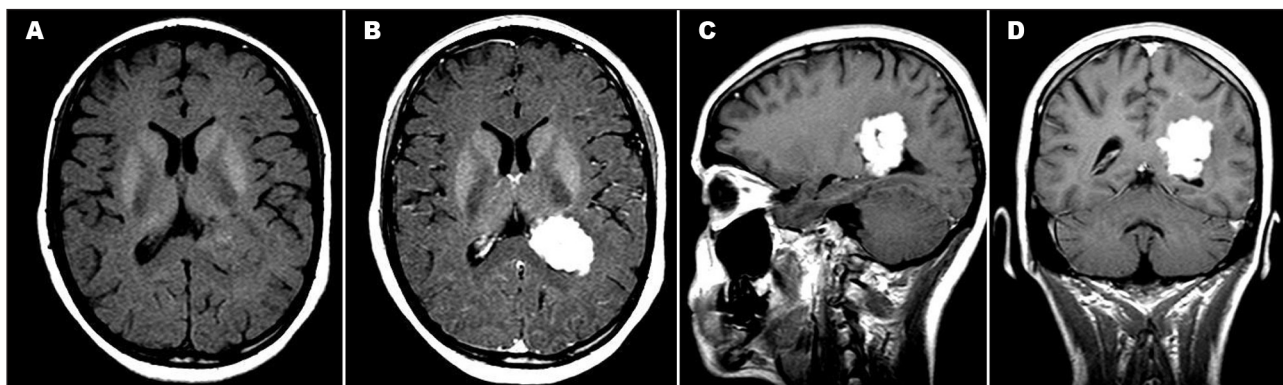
Brain T1-weighted MRI with a solitary 4 cm mass centred on the trigone of the left lateral ventricle. [A] Axial without gadolinium. [B] Axial with gadolinium. [C] Sagittal with gadolinium. [D] Coronal with gadolinium.
